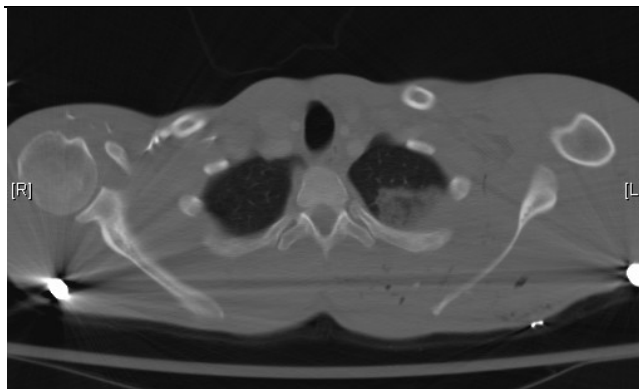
An example of nonoperatively treated gunshot wound to the upper back. Note the injury tract seen on this computed tomographic scan.
